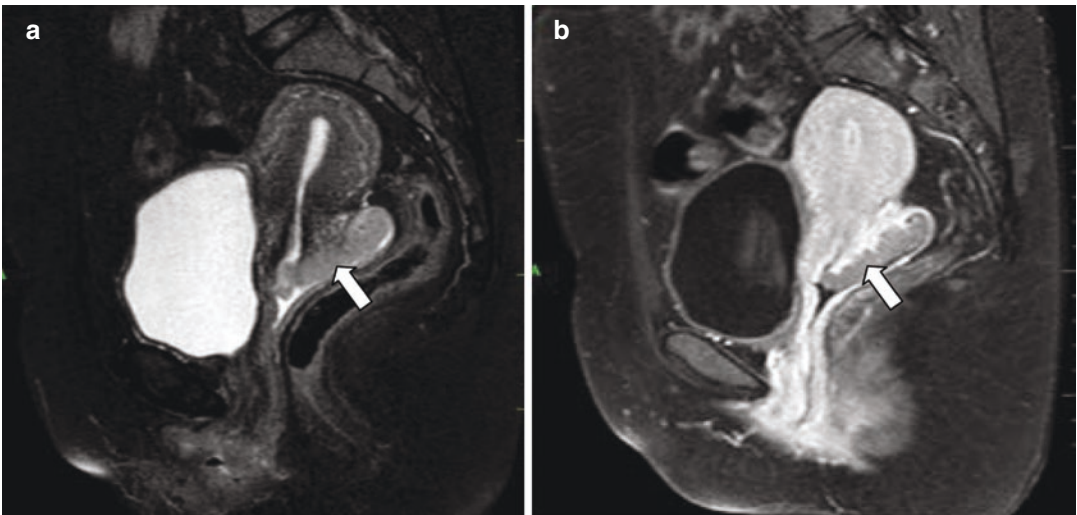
Cervical cancer. (a, b) T2W and T1 contrast MRI in sagittal sections showing a cervical mass involving the posterior lip of the cervix and extending towards the posterior vaginal fornix (arrows)
